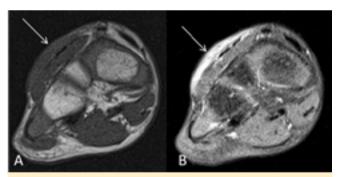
Companion case No. 1. A 5-year-old boy with a palpable lump. An ill-defined subcutaneous mass of the dorsal forefoot next to the extensor tendons of the toes (arrow) was isointense to muscle on a T1-weighted coronal image (A) and hyperintense on a coronal PDFS image (B).
